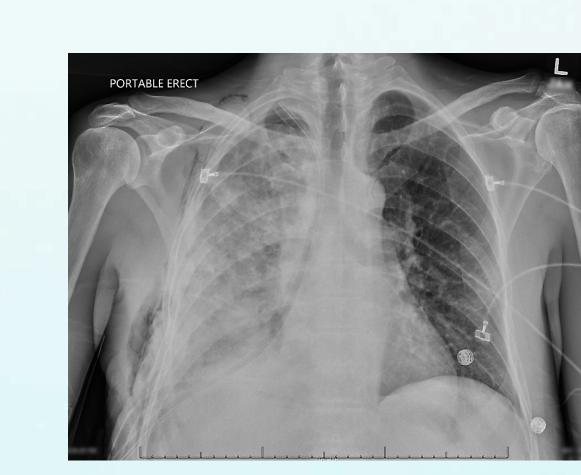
Chest x-ray showing improved aeration after decortication of the right lung.
